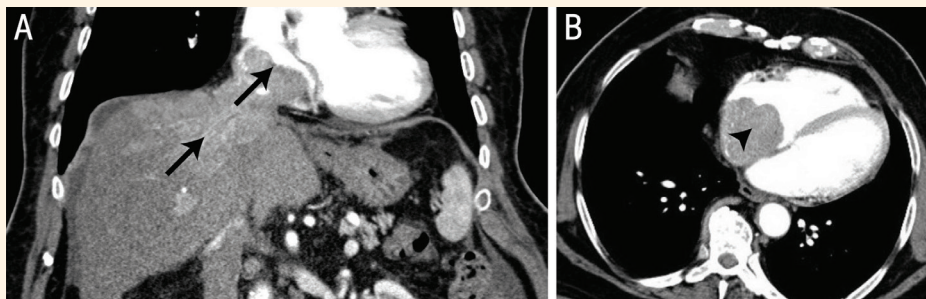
A: Computed tomography (CT) scan of the abdomen and chest of an 82-year-old man in the coronal view showing a hepatocellular carcinoma migrating through the inferior *vena cava* to the right atrium (arrows). B: Chest CT scan showing a tumour *thrombus* in the right atrium (arrowhead).
